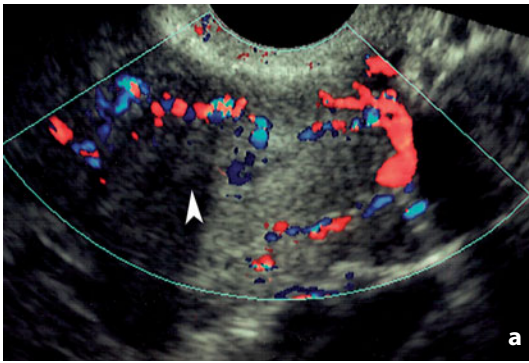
Transvaginal ultrasonography. Color Doppler. Woman of fertile age, follicular phase of the menstrual cycle. Normal vasculature of the uterine fundus (a, axial scan), the uterine body (b, longitudinal scan) and uterine cervix (c, longitudinal scan). The *arrowhead* indicates the uterine cavity
